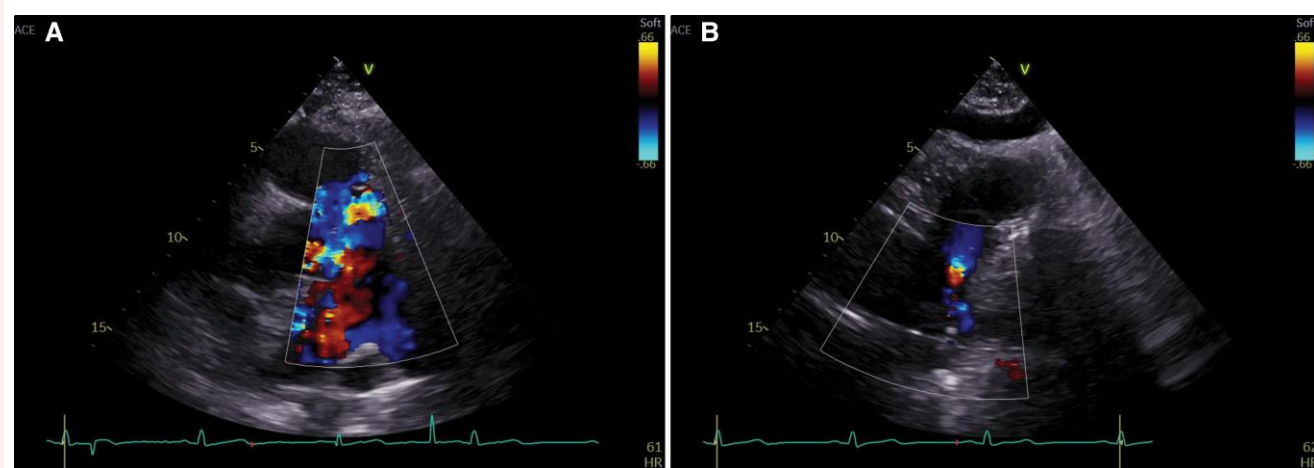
Off-axis parasternal short-axis echocardiographic views on Colour-Doppler demonstrating turbulent flow within the pulmonary trunk in Panel A and an abnormal communication between the aortic arch and the pulmonary trunk in Panel B, consistent with a left-to-right shunt.
